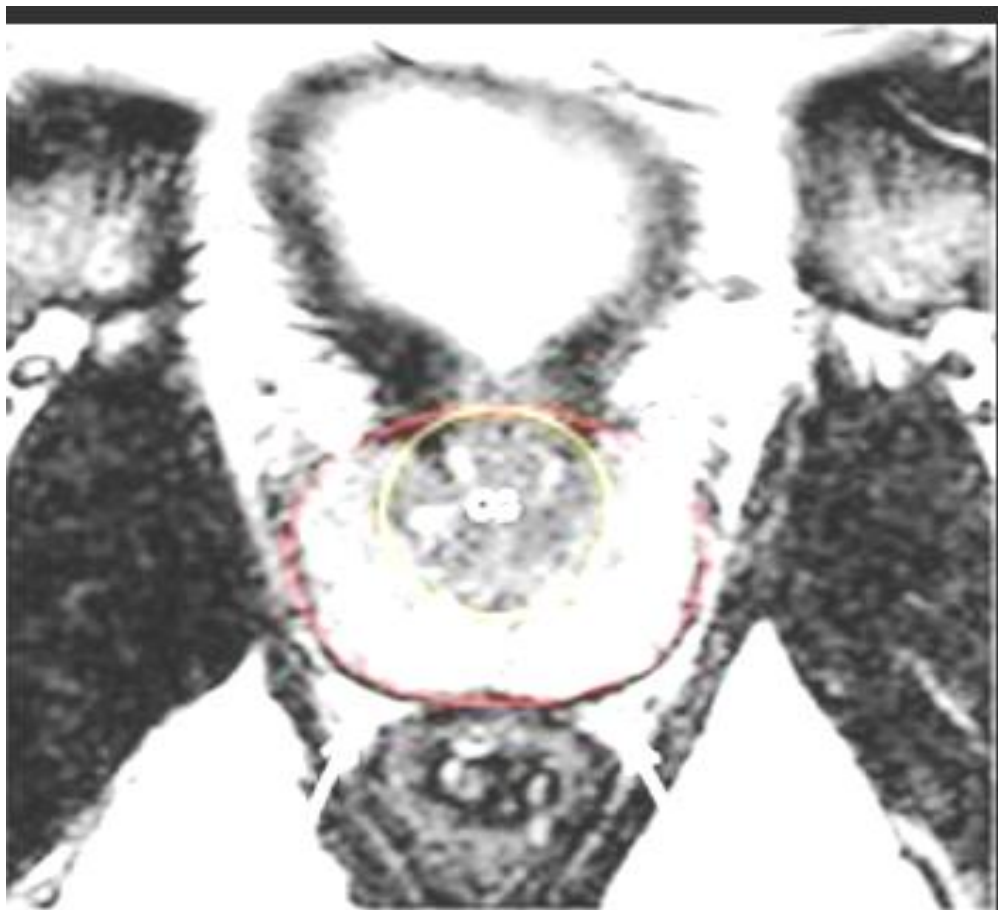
Normal prostate MRI
